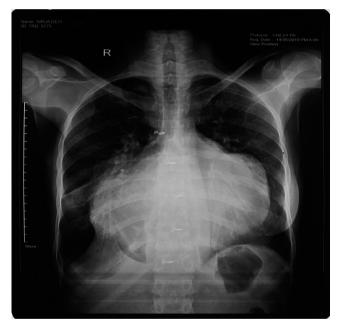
Chest radiograph in PA view showing massive cardiomegaly. The left heart border showed prominent main pulmonary artery and left atrial appendage. The apex could not be commented upon. The right heart border showed double contour of atrial shadow
